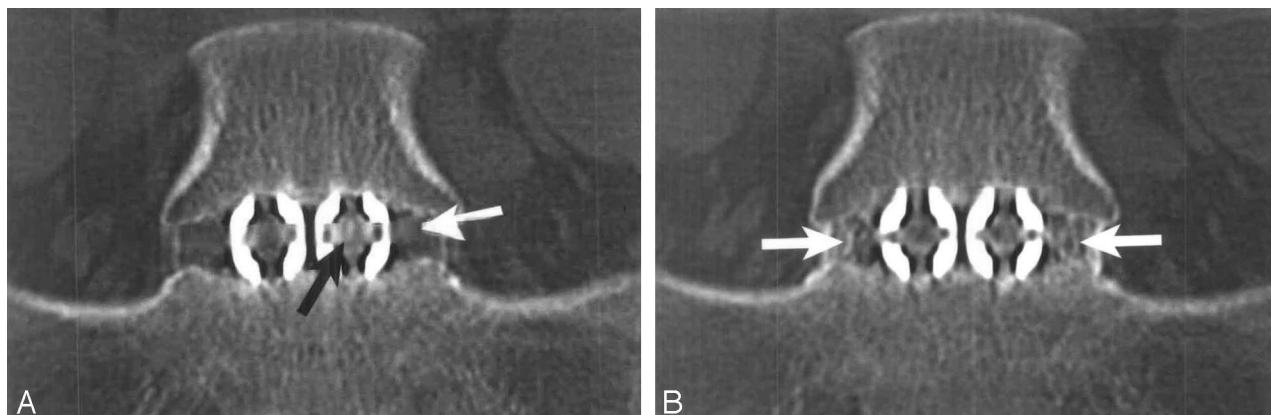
Normal progression of interbody fusion in a 28-year-old woman. A, On a coronal reformatted CT image, obtained 6 months after surgery, new bone formation is evident within (black arrow) and adjacent to (white arrow) the LT-CAGE devices. B, Ten months after surgery, reformatted CT image shows additional new bone formation, especially lateral to the fusion devices (white arrows), with bony bridging across the disk space.
